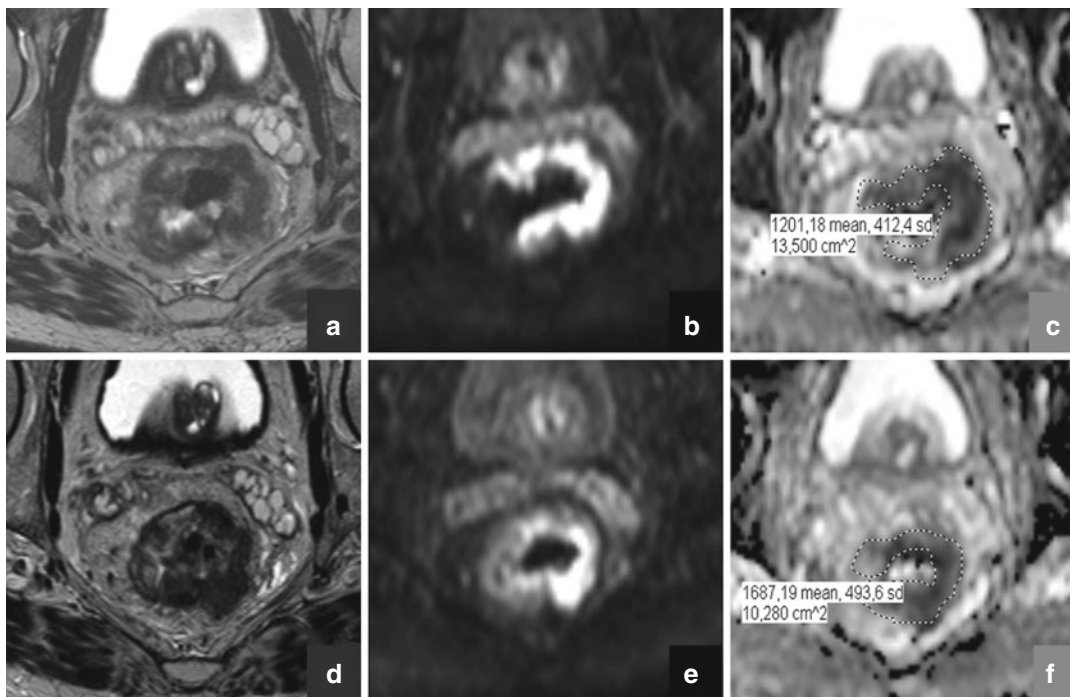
Early therapy assessment by diffusion-weighted imaging (DWI). Example of a patient with a rectal tumor at primary staging (a–c) and early during neoadjuvant treatment, after 2 weeks of chemoradiotherapy (d–f). On T2-weighted MRI before treatment (a), a circular T3 tumor is visible. After 2 weeks of treatment (d), no apparent changes in tumor shape, signal intensity, or volume can yet be detected. On high b-value (b1000) DWI before treatment (b), the tumor is easily detectable because its high signal intensity – indicating restricted diffusion – makes it stand out compared to the suppressed
